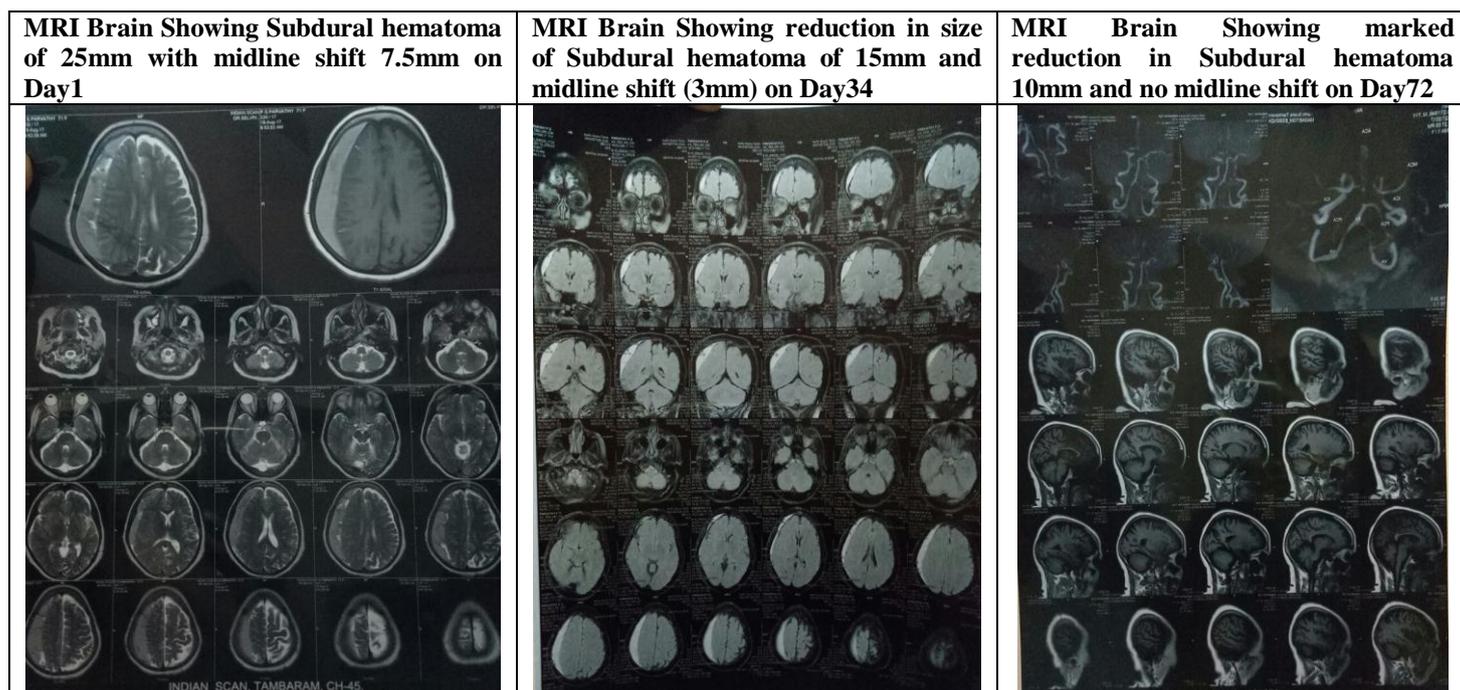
Initial MRI Brain Showing Subdural hematoma on Day1 and its prognosis following Leech therapy in Day 34 and Day 72.
